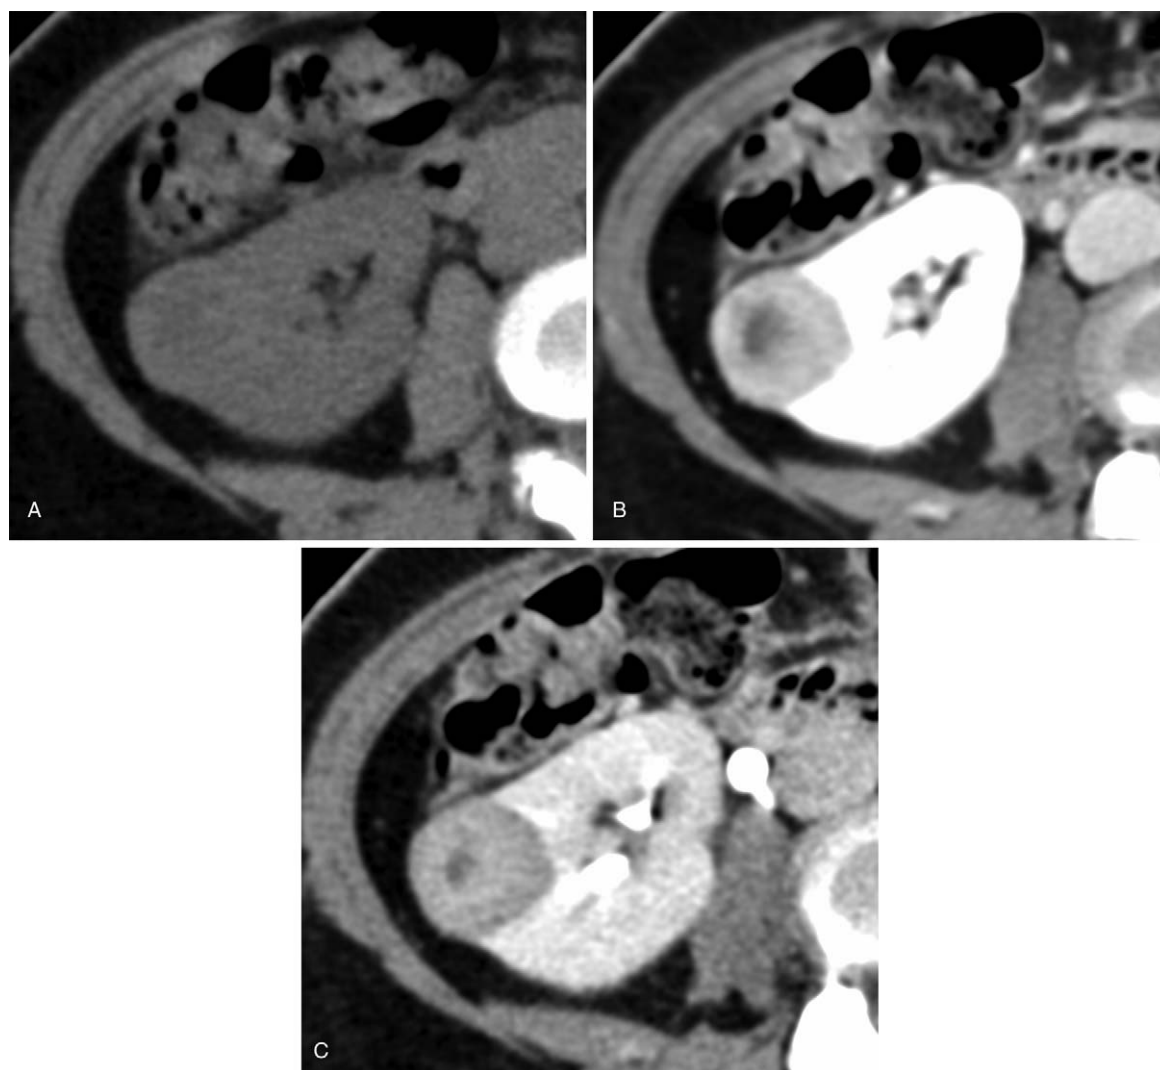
Computed tomography (CT) of the right kidney. (A) Non-enhanced CT shows an exophytic nodule at the mid-pole of the right kidney. The tumor was measured 40 Hounsfield unit (HU), slightly dense than adjacent renal parenchyma. (B) Medullary and (C) delayed phase contrast CT shows a well-circumscribed, hypovascular tumor with cystic component. Enhancement of the tumor was less than that of right renal cortex and medulla in all phases.
